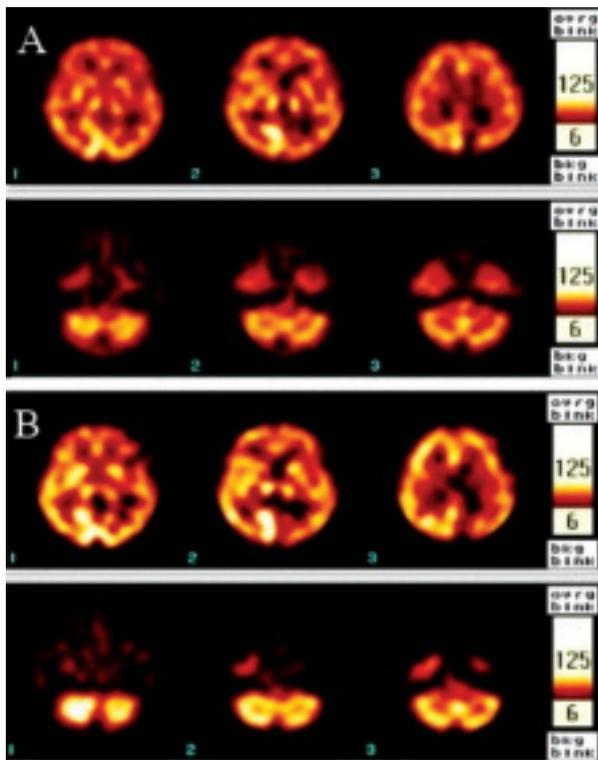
Brain SPECT with ^{99m}Tc-HMPAO images obtained on May 10, 2004 (A) and on October 4, 2004 (B). In (A), inhomogeneous perfusion in the cerebral cortex with decreased uptake of tracer in both frontal, left fronto-temporal region, as well as left occipital lobe (upper). The cerebellum looks like normal (lower). In (B), inhomogeneous perfusion in the cerebral cortex with relative decreased uptake in left hemisphere, including the left frontal, temporal and left parietal-occipital regions (upper). However, the left cerebellum shows relatively decreased uptake (lower).
